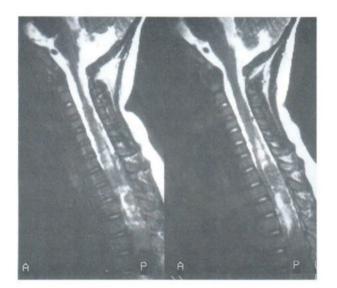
MRI of cervical spines in bilateral retinoblastoma shows intramedullary metastais of cervical cord.
